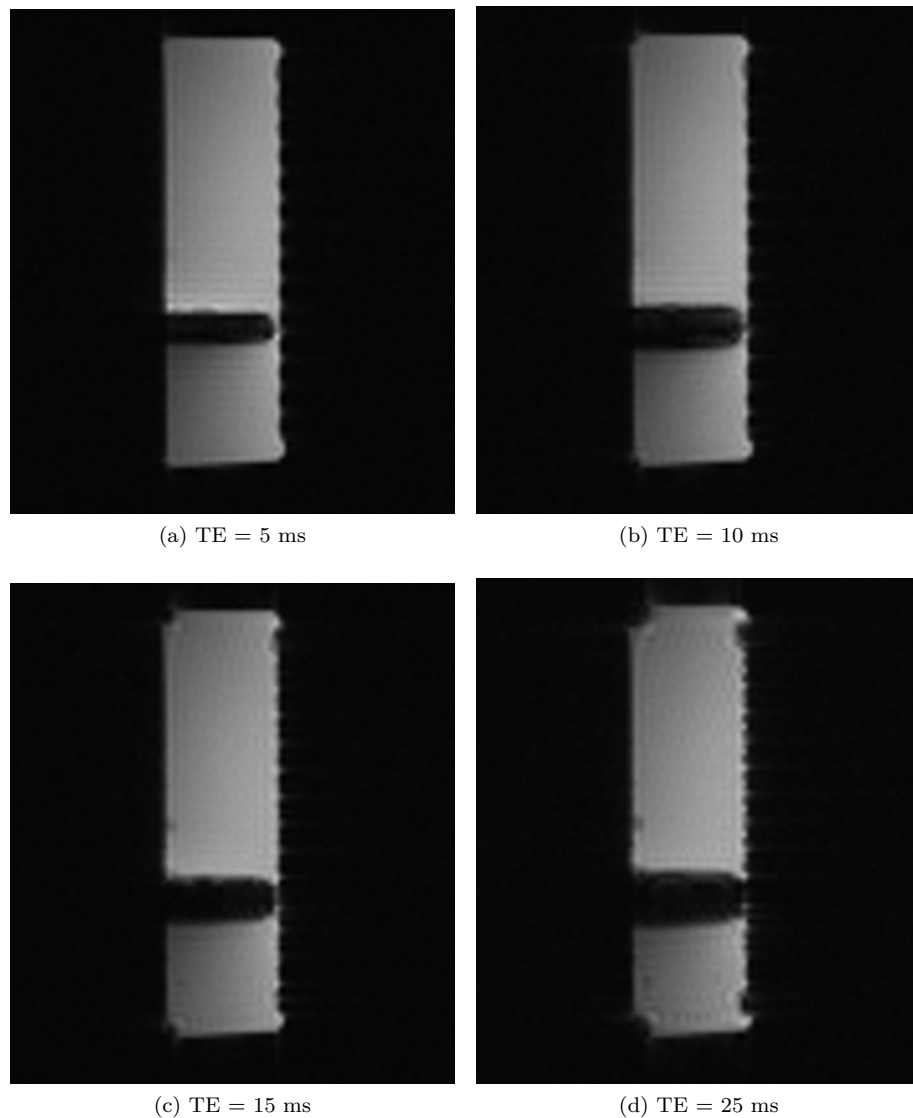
MR images of a cryoneedle, 17Gauge, GALIL MEDICAL, Yokneam, Israel, acquired with needle shaft orientation orthogonal to the main magnetic field and TE respectively equals to TE, 5.0, 10.0, 15.0, 25.0 ms; The other parameters remained unchanged for all the series acquired. TR, 51 ms; BW, 601 HzPx1⁻¹; Flip angle, 25°; Spacel resolution, 2.3x2.3x5mm. Images were acquired during an experiment session of this work at Siemens MR, Erlangen, Germany, with Eva Rothgang.
